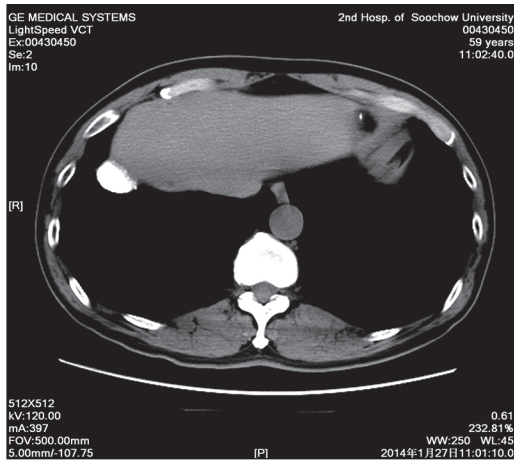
Multiple patchy dense shadows were observed on the sides of the diaphragm, one of which was spindle-like with a diameter of 18.2 mm × 28.98 mm × 9.53 mm, as seen on computed tomography
